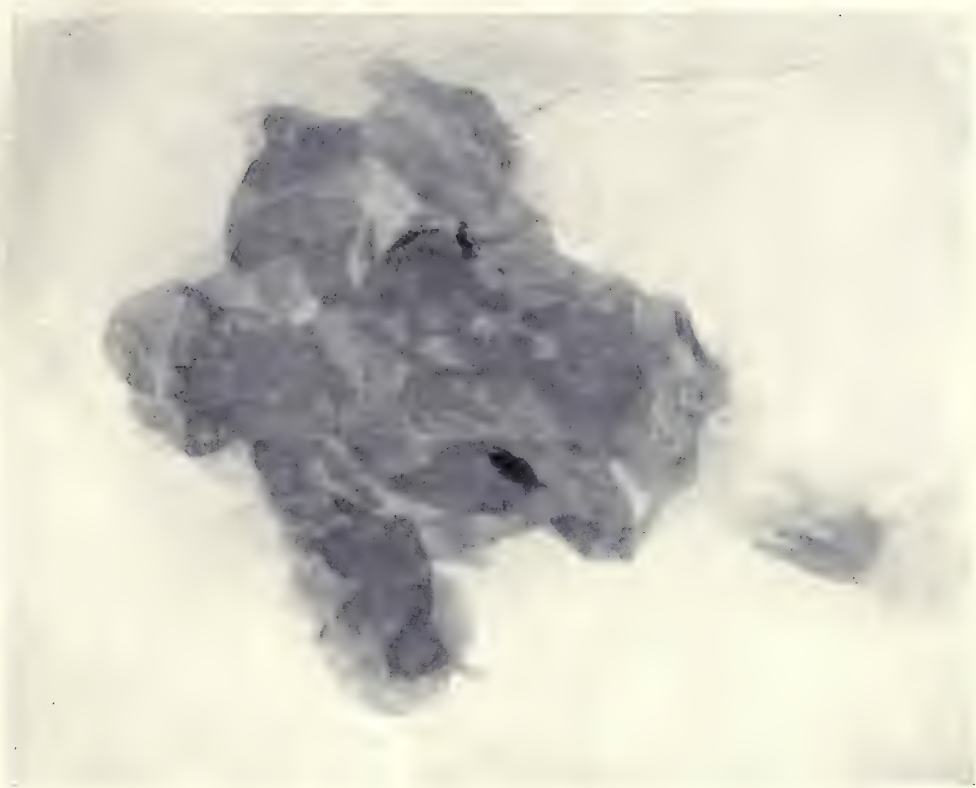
Radiograph of dermoid cyst and contents after its removal.
